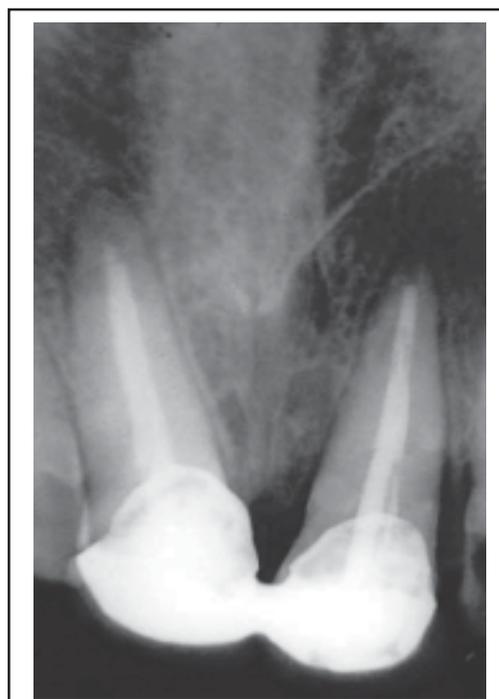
Six months radiographic assessment
